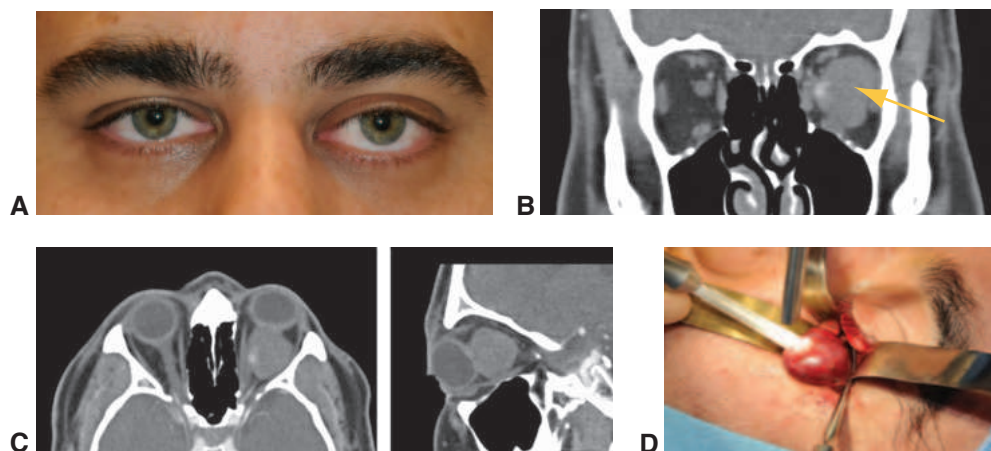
Cavernous venous malformation (CVM). A, Proptosis of the left eye as a result of CVM. B, Coronal computed tomography (CT) scans show a well-circumscribed lesion in the muscle cone (arrow). C, Axial (left) and sagittal (right) CT scans show the intraconal mass. D, Intraoperative traction with a cryoprobe facilitates complete removal of the mass. (Courtesy of Bobby S. Korn, MD, PhD.)
